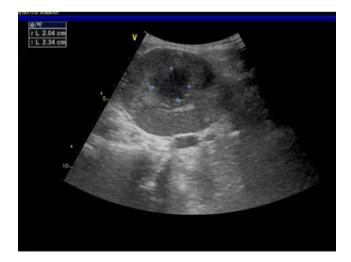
Multiple heterogeneous echo foci and poor blood perfusion in the transplanted kidney. The figure shows multiple heterogeneous echo foci observed in the transplanted kidney. The larger area measures approximately 2.3 cm × 2.0 cm. Color Doppler flow imaging (CDFI) and contrast-enhanced ultrasound (CDE) reveal poor blood perfusion in the affected regions.
